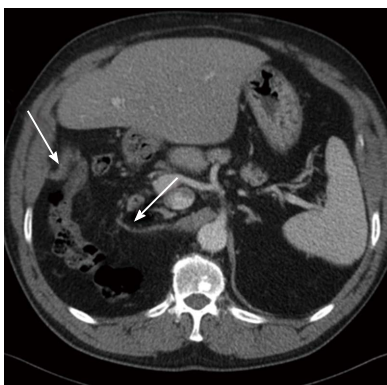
Computed tomography findings in blunt diaphragmatic lesions - dangling diaphragm sign. This 3 mm thick multiplanar axial reconstruction shows the free edges of a torn diaphragm as “comma-shaped” structures (arrows) which curl inward, toward the center of the abdomen. This alteration represents the so-called “dangling diaphragm sign”.
